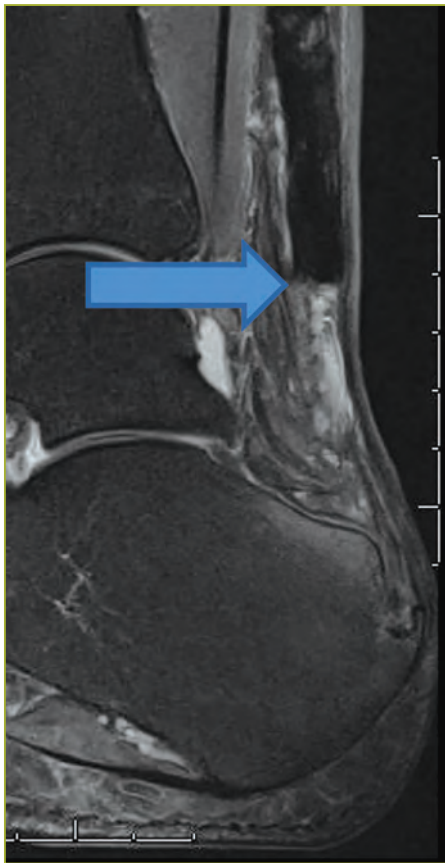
Magnetic resonance imaging (MRI) scan showing the end of an Achilles tendon (arrow), which was avulsed from the calcaneus without the distal tendon present for suture repair. MRI scans were obtained in 13 of the 37 (35%) patients included.
